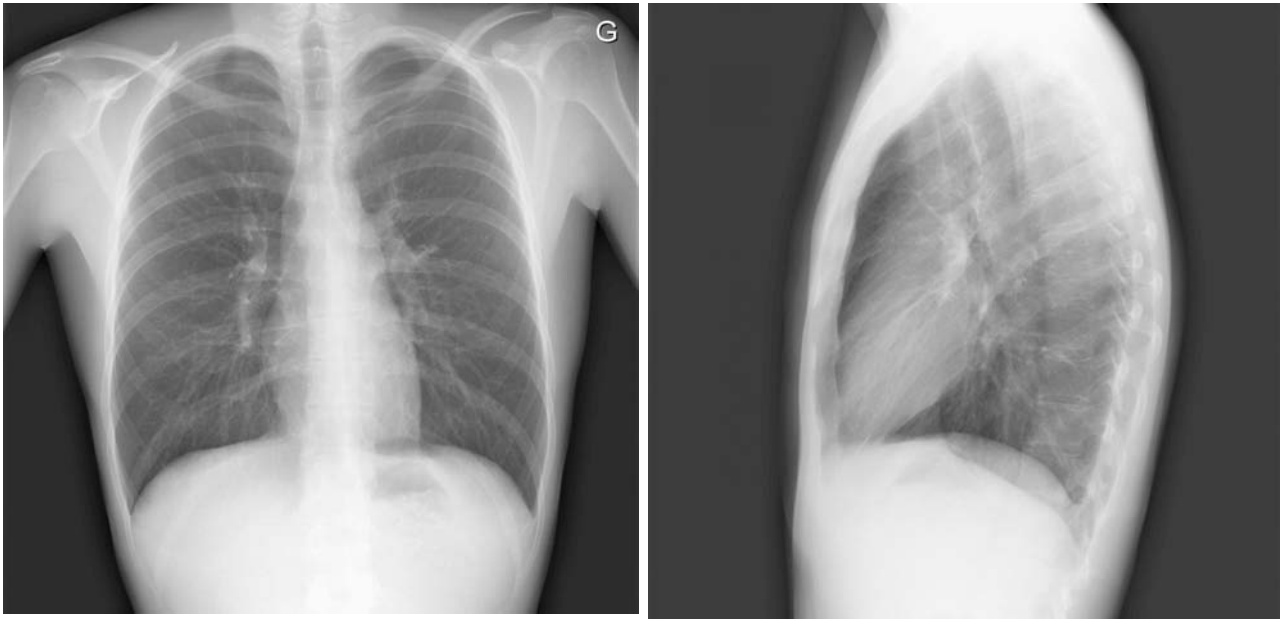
19-year-old. Female Digital Radiography (DR).
